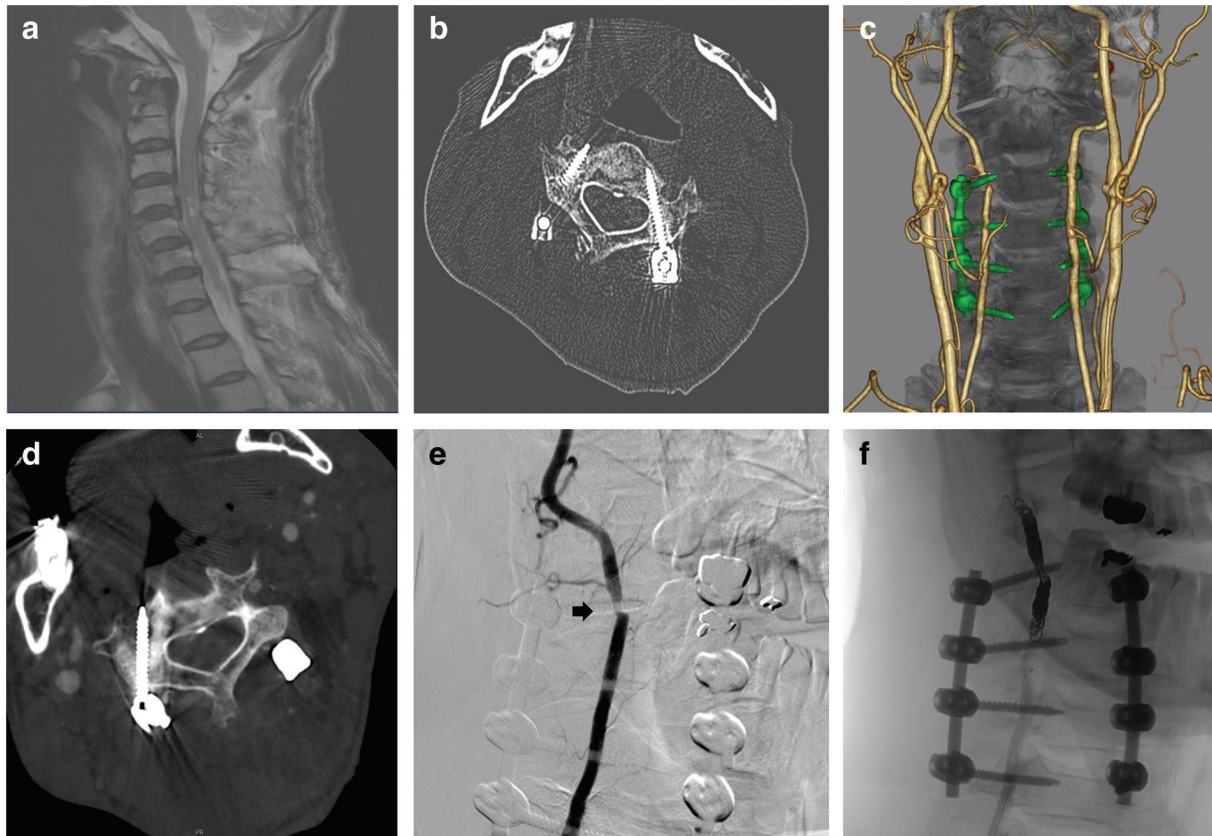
(a) Magnetic resonance image of the cervical spine showing cervical spondylosis. Posterior fusion was performed. (b) Postoperative CT scan showing the right C3 pedicle screw perforating the transverse foramen. (c) Postoperative CT angiogram showing a right VA stenosis at the screw insertion site. The left VA was larger in diameter than the right VA. (d) It was difficult to judge from axial image of CT angiogram whether the screw had caused intima damage. (e) Right VA angiogram showing a 70% stenosis at the screw insertion site (arrow). (f) Coil embolization. CT: computed tomography, VA: vertebral artery.
